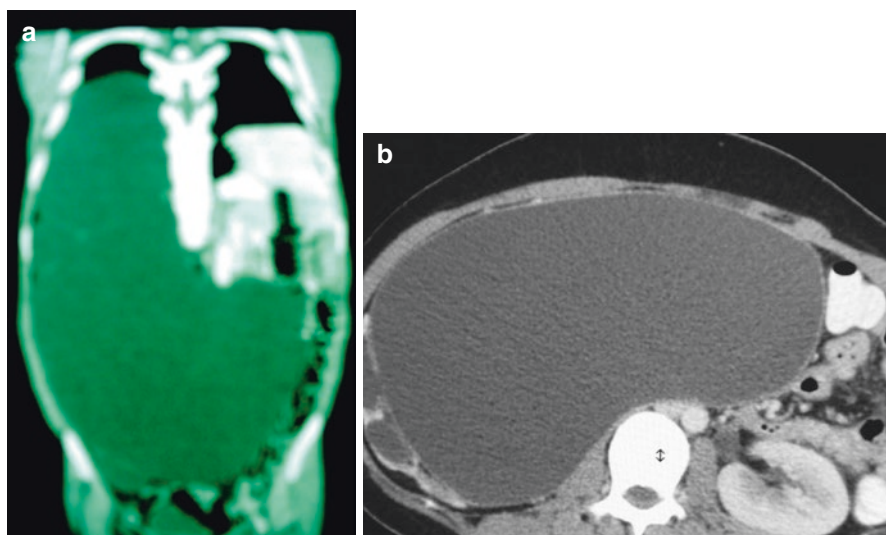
(a) Preoperative CT with IV contrast showing right-sided giant hydronephrosis occupying the whole abdomen and displacing abdominal contents. (b) Right-sided giant hydronephrosis with no contrast excretion. Notice the normal average-sized left kidney
